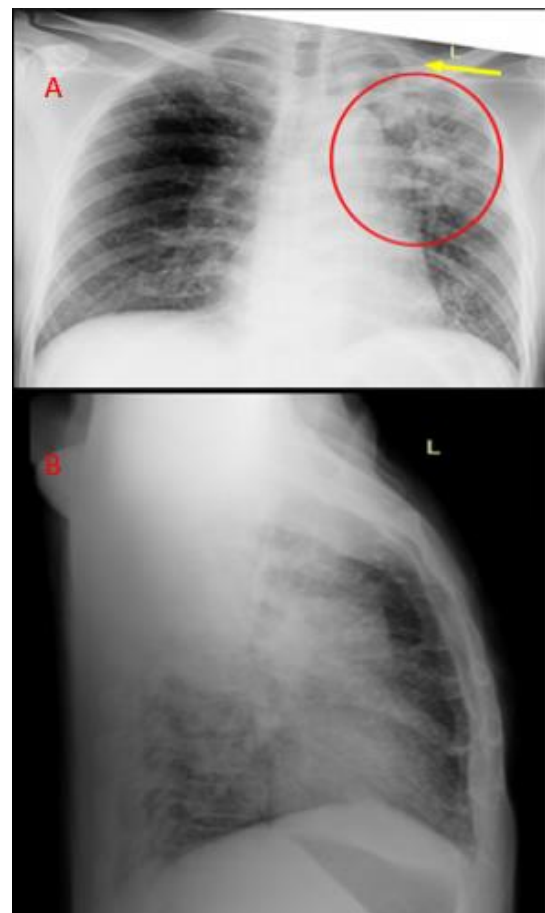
Chest X-Ray at the Anteroposterior and Lateral Position.
